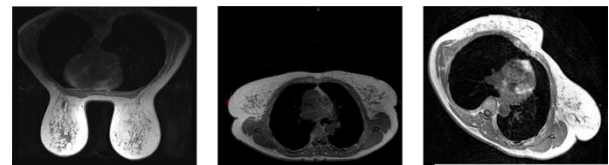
MR images for three breast configuration: a) prone position; b) supine position c) oblique supine.
